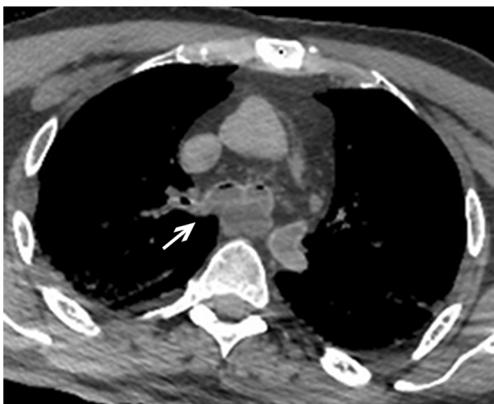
Post-mortem axial CT scan of the chest, at the level of the carina, in mediastinal window. The right and left main stem bronchi and the esophagus are partially filled with fluid (*white arrow*)
